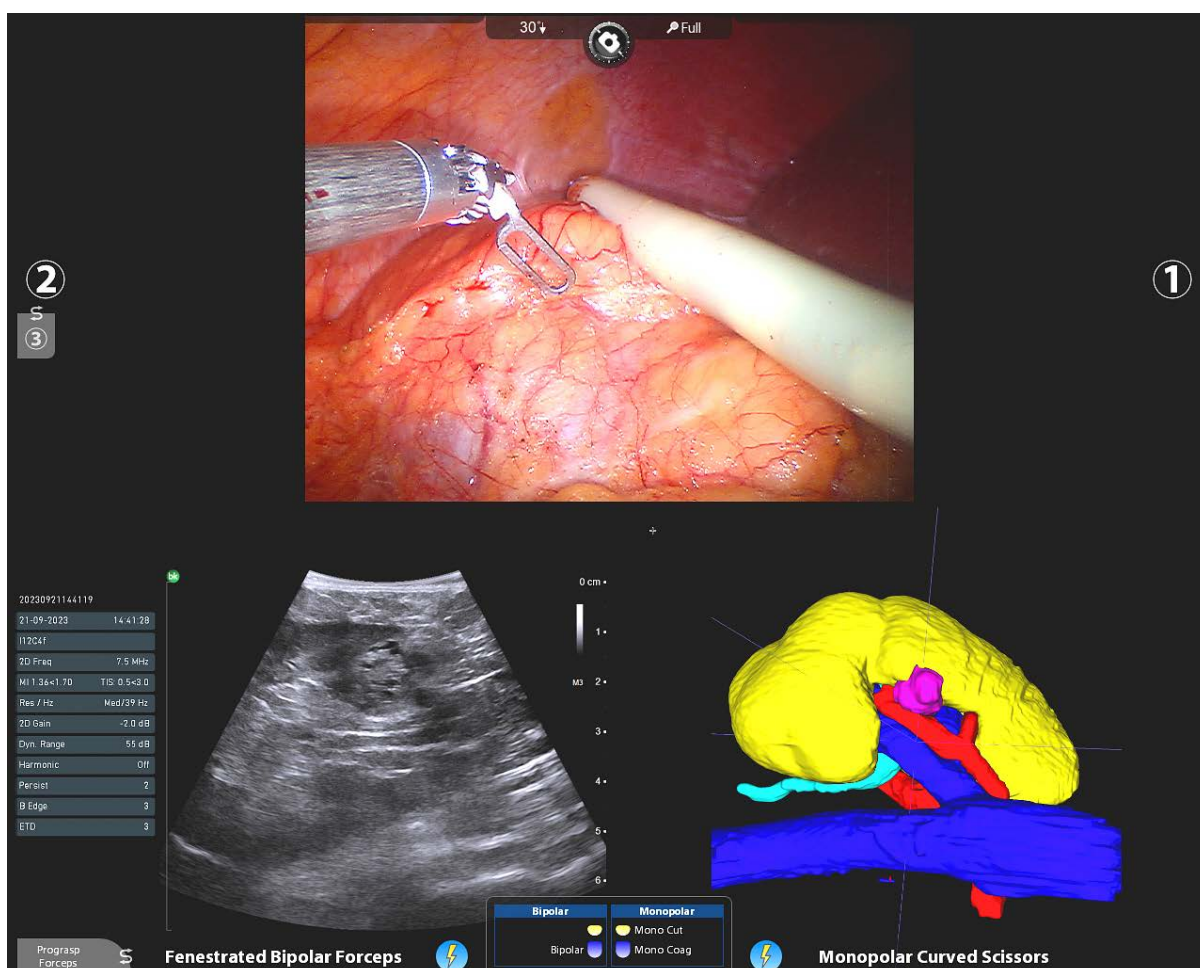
Intraoperative console view showing the surgical view, intraoperative ultrasound, and 3D virtual model as "picture-in-picture" views using the TilePro function of the da Vinci Si Surgical System
